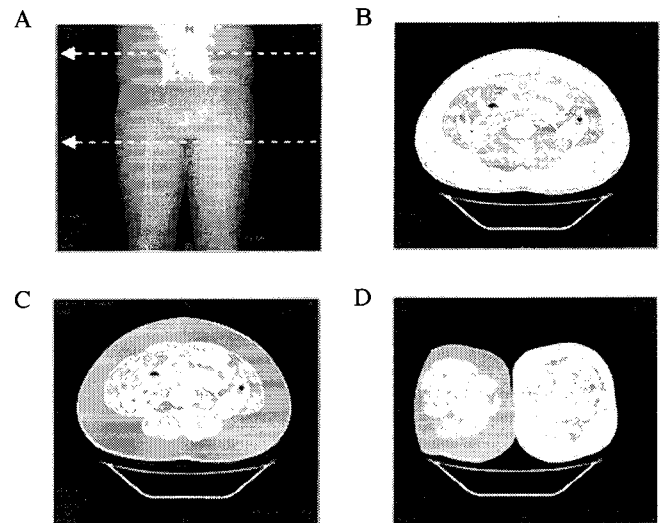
Measurement of cross-sectional fat area using CT. (A) Abdominal and thigh positions for cross-sectional fat area measurement. (B) An example of total abdominal fat area. (C) An example of visceral fat area. (D) An example of thigh subcutaneous fat area.
